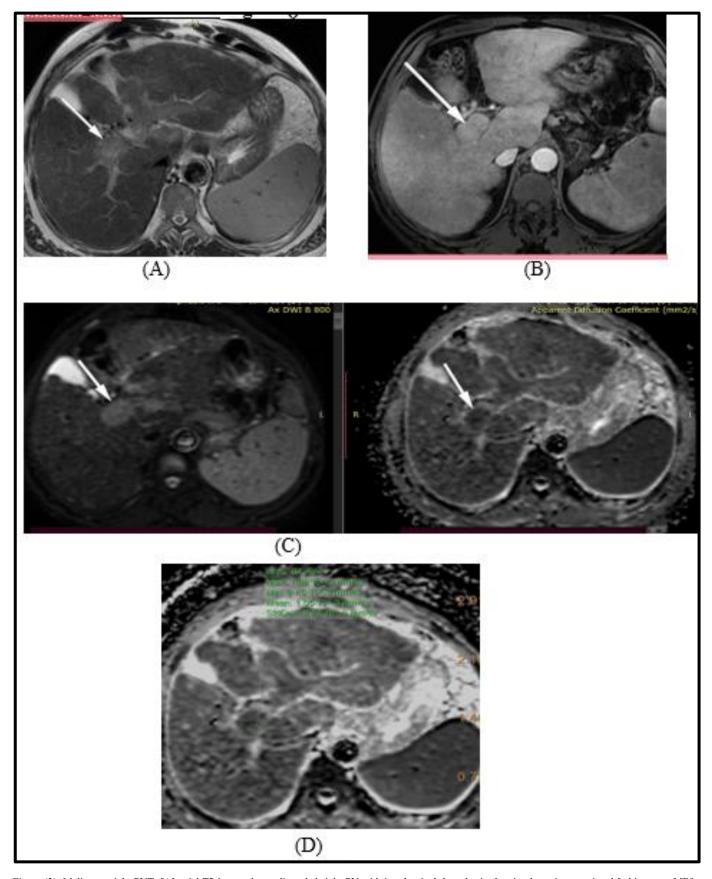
Malignant right PVT :[A] axial T2 image shows distended right PV with intraluminal thrombosis showing hyperintense signal [white arrow].[B] axial post contrast arterial enhancement showing enhancement of the thrombus similar to HCC [white arrow]. [C] DWI&ADC map images of PVT showed diffusion restriction. [D] On ADC, the signal intensities within the thrombus were measured and the value of main PVT was $1.05 \times 10^{-3} \, \text{mm}^2/\text{sec}$
